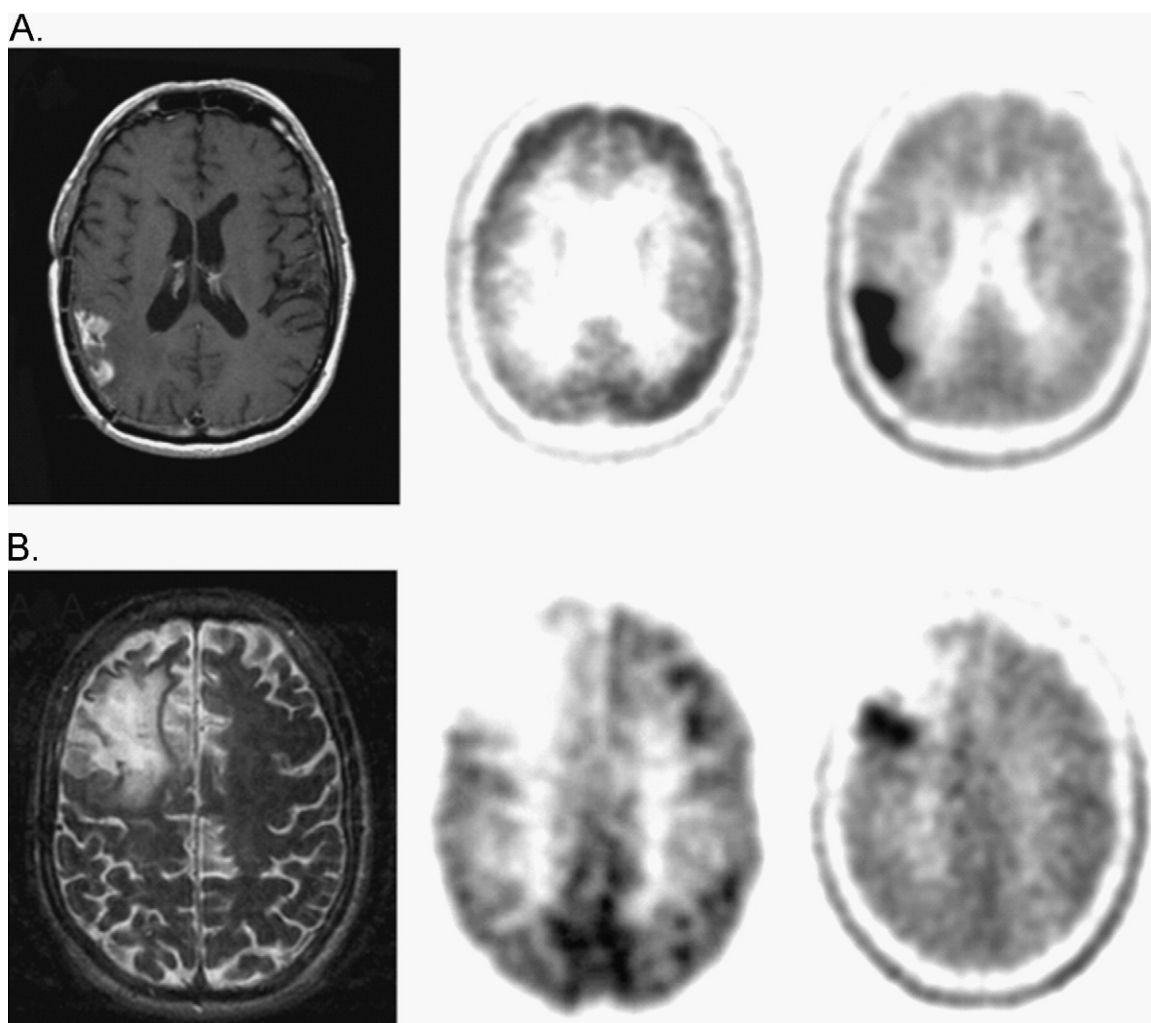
MRI, FDG-PET, and FDOPA-PET in evaluating recurrent tumors. (A) Recurrent glioblastoma. (B) Recurrent grade II oligodendroglioma. (Reprinted by permission of the Society of Nuclear Medicine from Chen et al.⁷²)
